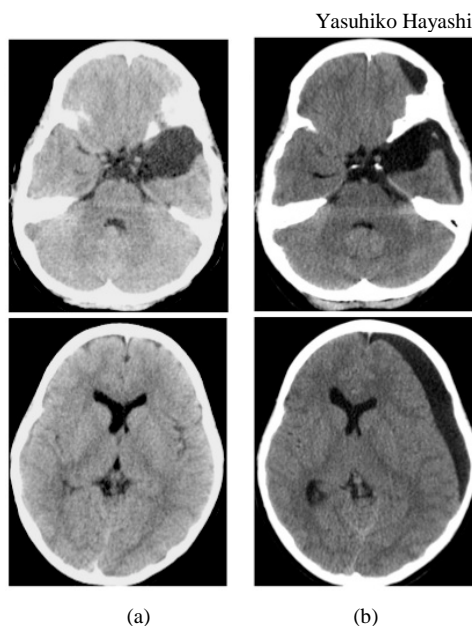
(a) A computed tomography (CT) scan of the head obtained when the patient encountered minor head trauma showed the arachnoid cyst located in the left middle fossa; no subdural hematoma was detected; (b) A CT scan of the head obtained at admission, 2 months after minor head trauma, showed a previously detected arachnoid cyst and subdural fluid collection with remarkable mass effect.
